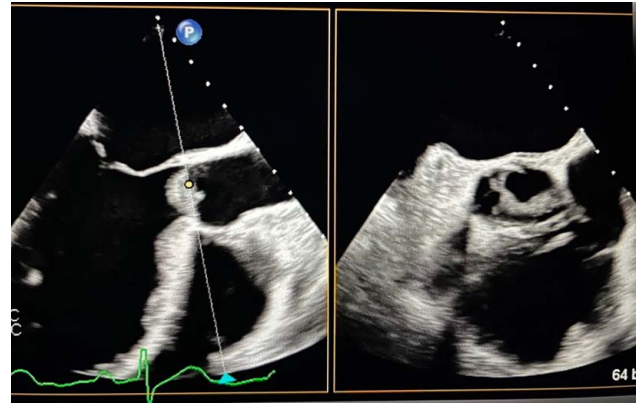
A transesophageal echo (TEE) showing vegetation in the Aortic valve.
